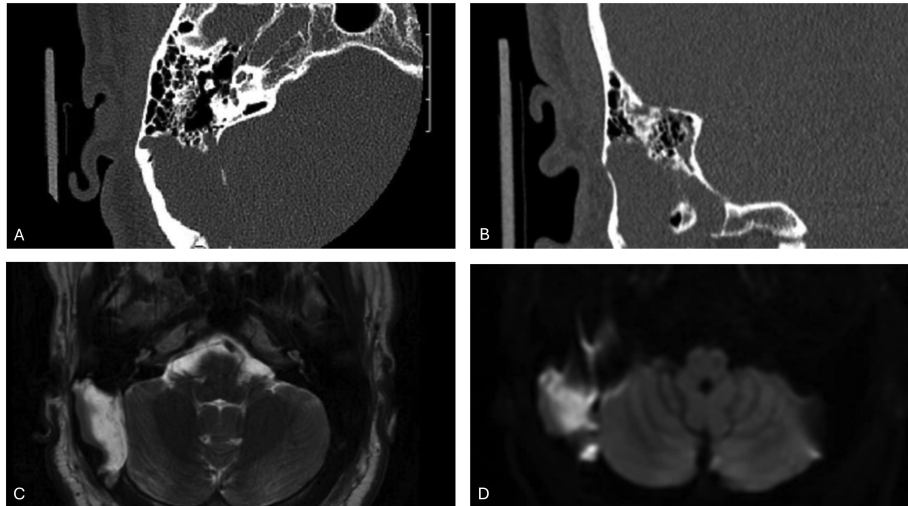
Preoperative axial (A) and coronal (B) non-contrast CT of the temporal bone, axial T2-weighted magnetic resonance imaging (C), and diffusion weighted imaging (D) demonstrating large right destructive lesion abutting the posterior fossa and eroding the sigmoid plate.
